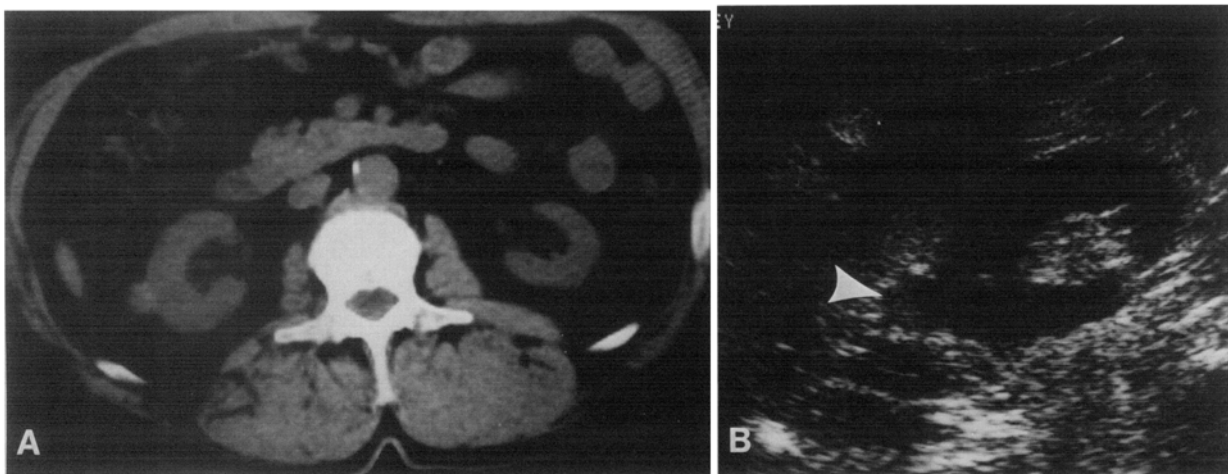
Indeterminate hyperdense mass (category III). Unenhanced CT (A) demonstrates a small, exophytic right renal mass. The mass is slightly heterogeneous. Contrast could not be administered in this case. Ultrasound shows that the mass (arrowhead) is not cystic. Nephrectomy confirmed that the mass was a renal cell carcinoma.
